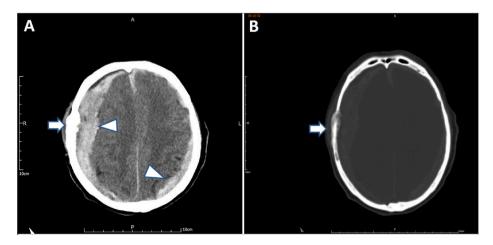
Photographs of CT scan of brain (A) indicates an osteoblastic lesion over the right frontotemporal bone (arrow) with bilateral subdual hematomas compressing on the brain (arrowhead). Bone window depicts an osteoblastic mass over the frontotemporal bone (B, arrow).
